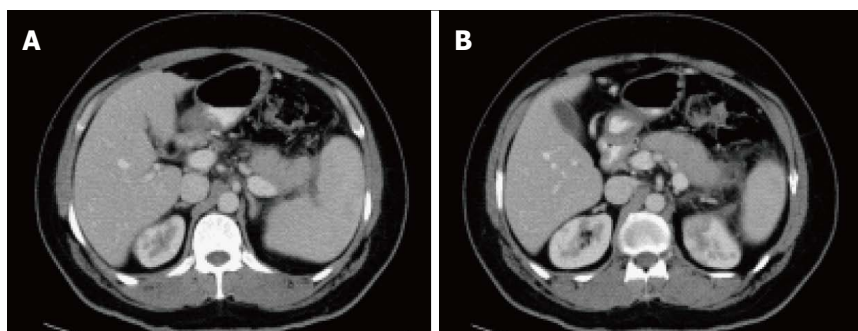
Autoimmune pancreatitis. A, B: Axial CT scan during the late arterial phase. There is evidence of diffuse pancreatic swelling with loss of the normal pancreatic lobulation, obliteration of the pancreatic duct and subtle low attenuating peripancreatic rim (A, B) in keeping with autoimmune pancreatitis. Patient had high IgG4 level (> 0.500 g/L).
